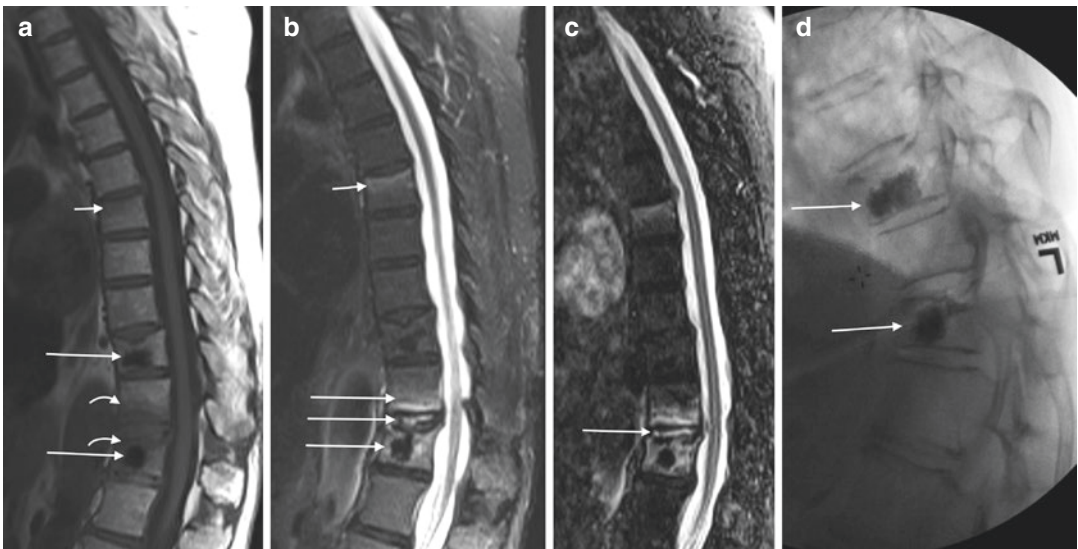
A 70-year-old female with history of osteoporosis and recent lower thoracic vertebral augmentation presents with severe upper thoracic back pain. T1-weighted sagittal image (a) shows round hypointense foci of low signal intensity (large arrows) at T9 and T11 from the recent vertebral augmentation procedures. Additionally, T1 hypointensity (curved arrows) is seen at the T10–T11 endplates. A subtle hypointense band of marrow edema is associated with mild height loss at T6 (small arrow). The T2 sagittal image (b) shows areas of hyperintense signal
